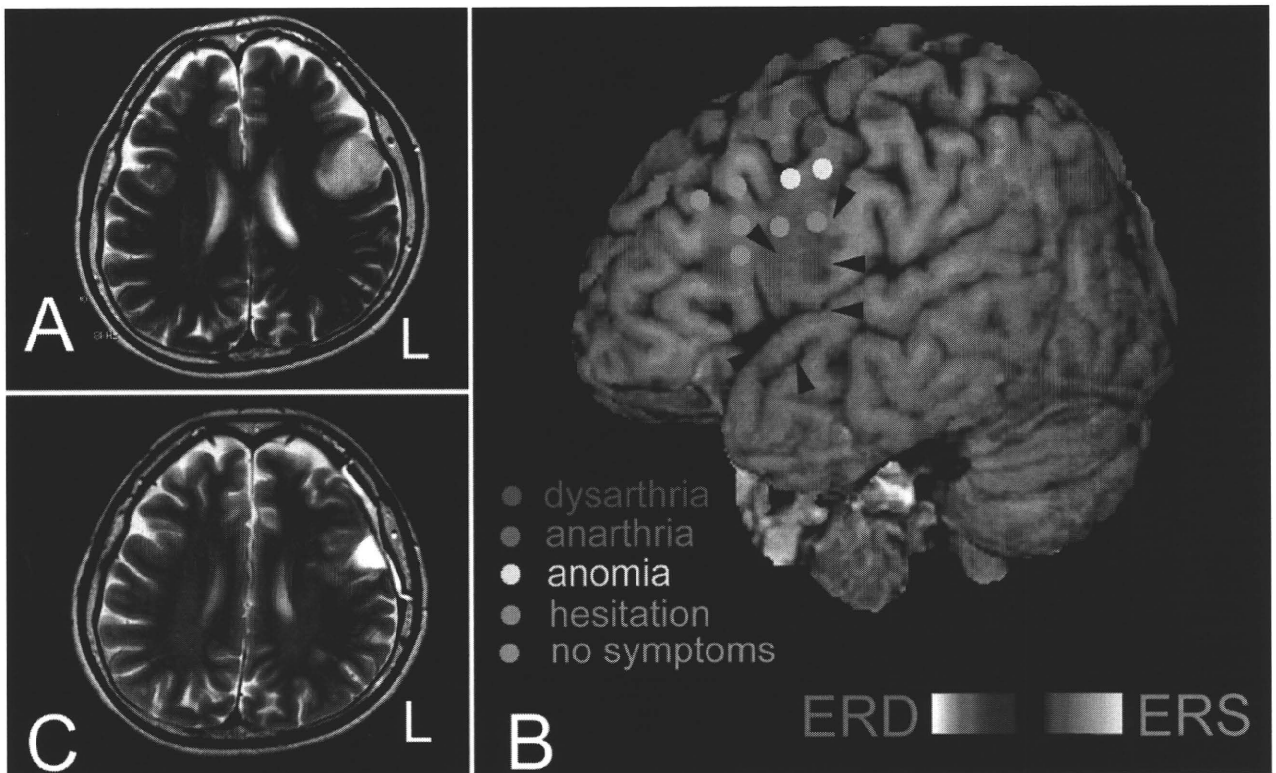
Case 10. Images obtained in a patient with an astrocytoma in the Broca area. A: Preoperative T1-weighted MR image demonstrating an astrocytoma. B: An MEG image showing language localization superimposed on an MR image. *Black arrowheads* indicate the tumor boundary. Stimulation sites, indicated as *colored dots*, were also superimposed on the MR image. *Magenta areas* indicate statistically significant ERD detected by MEG; *yellow areas*, statistically significant ERS detected by MEG. A p value < 0.001 was considered statistically significant. C: Postoperative T2-weighted MR image demonstrating no apparent mass lesion.
